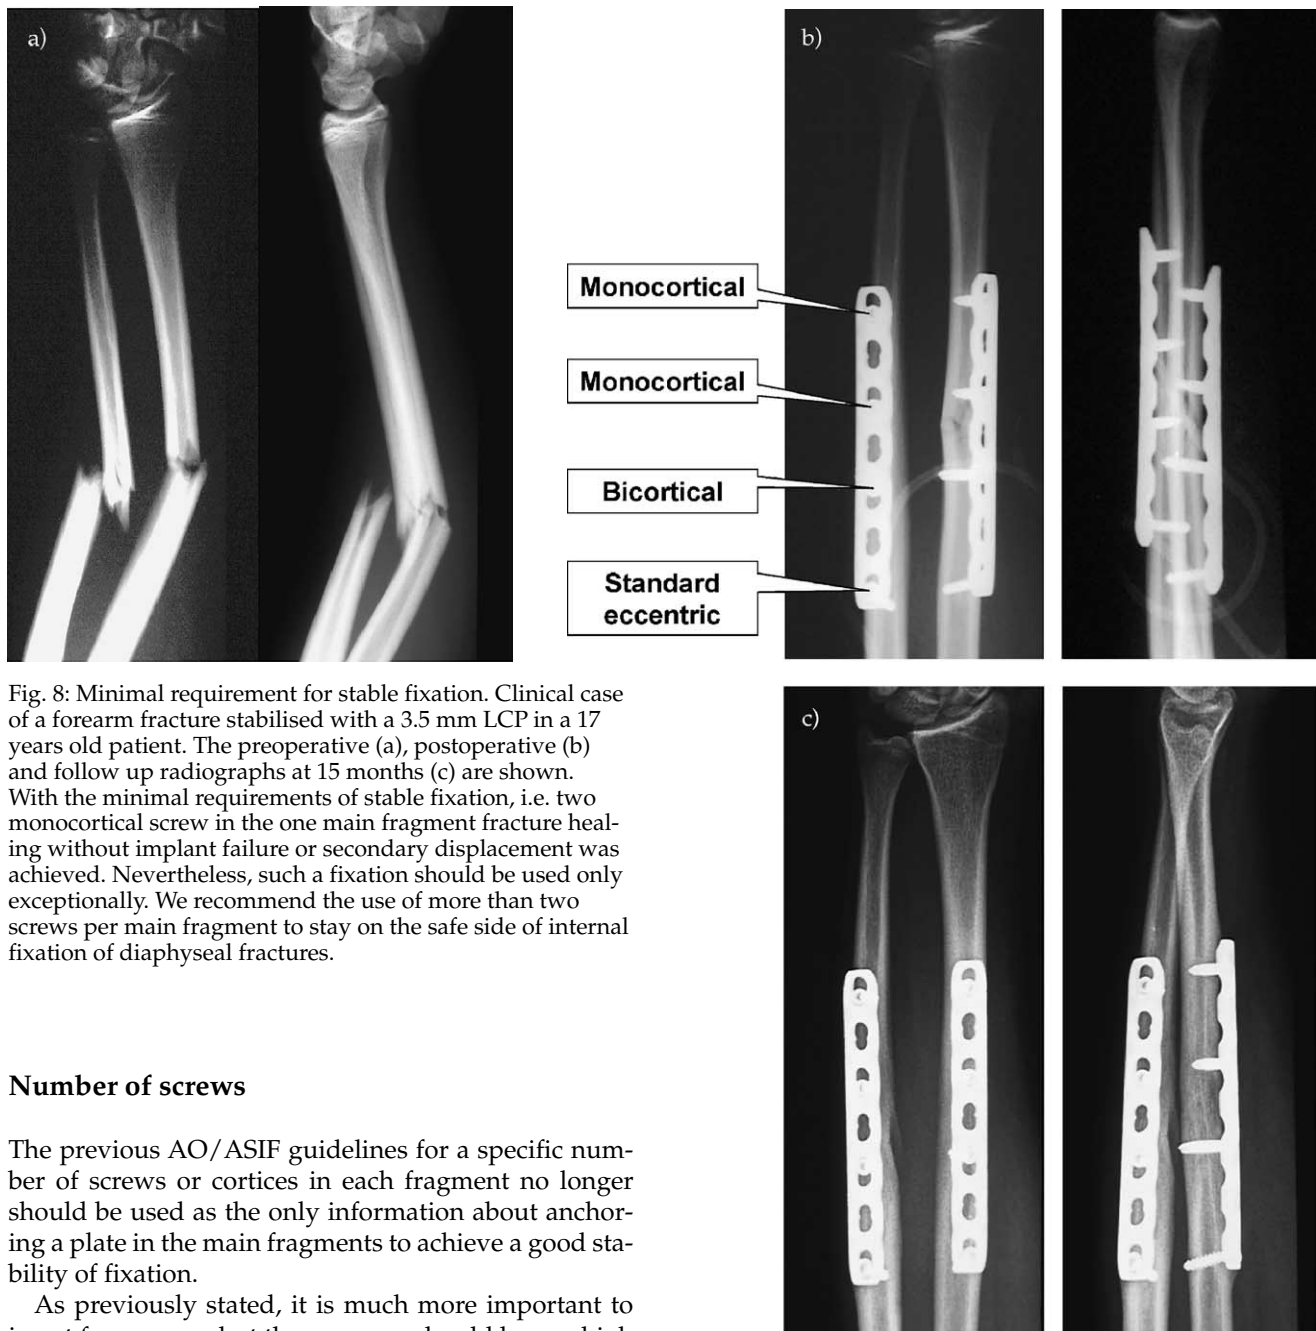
Minimal requirement for stable fixation. Clinical case of a forearm fracture stabilised with a 3.5 mm LCP in a 17 years old patient. The preoperative (a), postoperative (b) and follow up radiographs at 15 months (c) are shown. With the minimal requirements of stable fixation, i.e. two monocortical screw in the one main fragment fracture healing without implant failure or secondary displacement was achieved. Nevertheless, such a fixation should be used only exceptionally. We recommend the use of more than two screws per main fragment to stay on the safe side of internal fixation of diaphyseal fractures.
